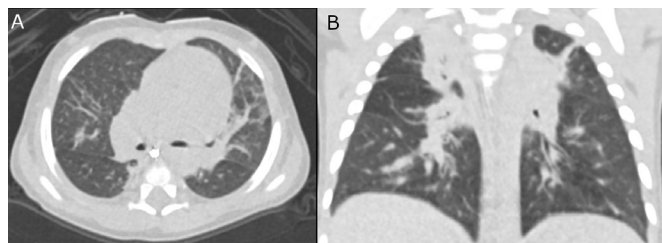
Chest CT (A) axial and (B) coronal sections show ground glass opacities and patchy pulmonary consolidations.
